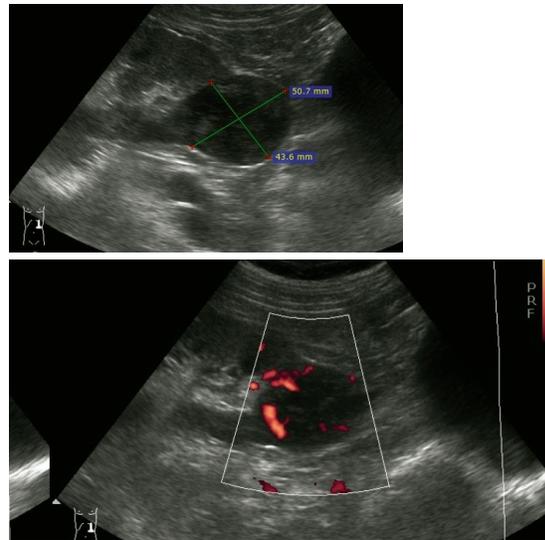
Grey-scale and Doppler US at the initial presentation. Well-delimited tumor with exophytic pattern and spoke-wheel distribution of the vascularization
